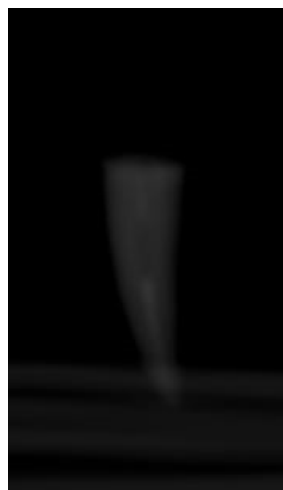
16 CBCT evulion of post placement( castable post) Fig ; 17 CBCT evulion of post placement( 3Dprinted post)
